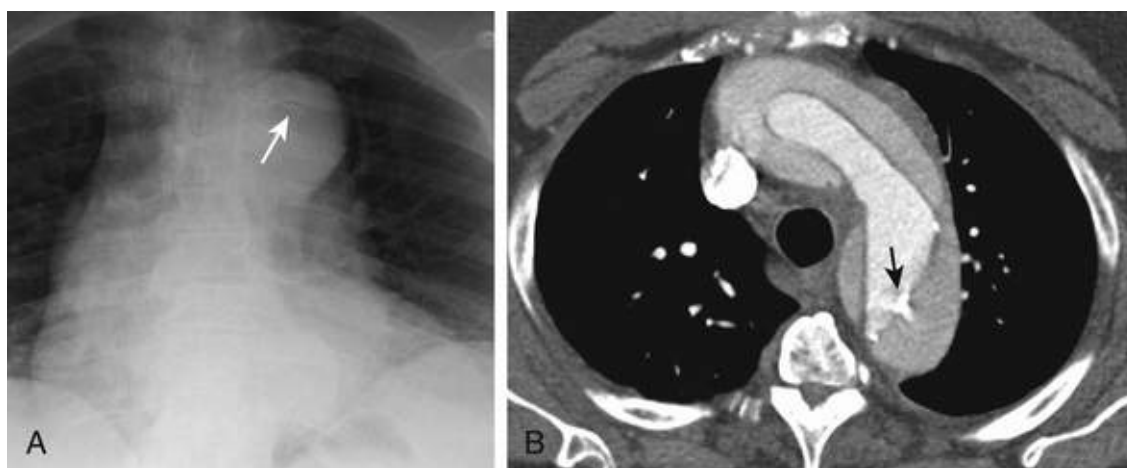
Mediastinal hematoma. Coned-down AP radiograph of young man who was a driver in a motor vehicle accident shows mediastinal widening (*arrows*) caused by acute traumatic aortic injury, which caused a large mediastinal hematoma. The displacement of the paravertebral line on the left extends to the left lung apex (“apical capping”). Note that the trachea is deviated to the right, and the left main bronchus is displaced inferiorly.
